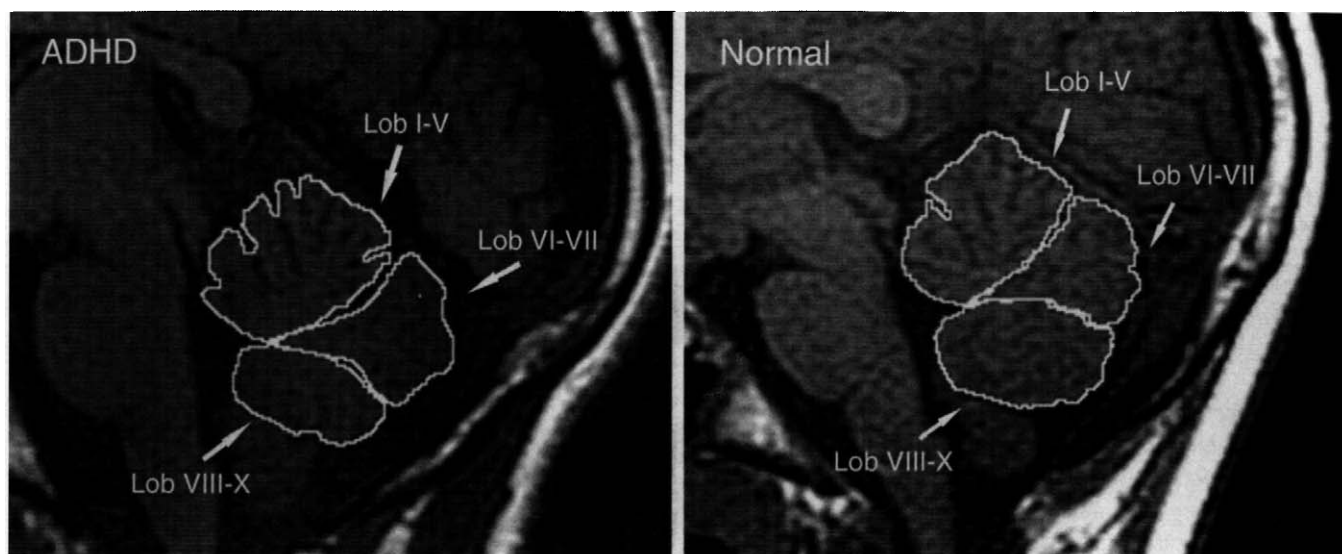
Midsagittal magnetic resonance images of a male with ADHD and a normal male control patient. Borders are drawn around the anterior cerebellar vermis (lobules I-V); and lobules VI-VII and lobules VIII-X of the posterior cerebellar vermis. The area of the inferior posterior cerebellar vermis (lobules VIII-X) appears to be smaller in the male with ADHD.
